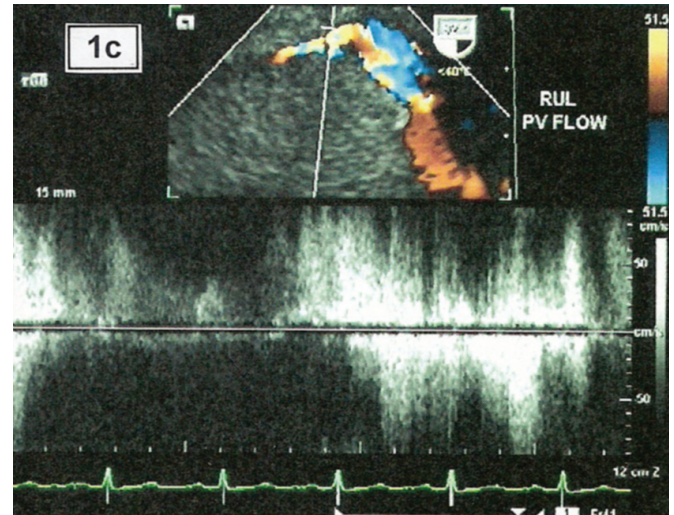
Transesophageal echocardiographic view showing generalized hypoplasia of right upper pulmonary vein with continuous turbulent flow.
